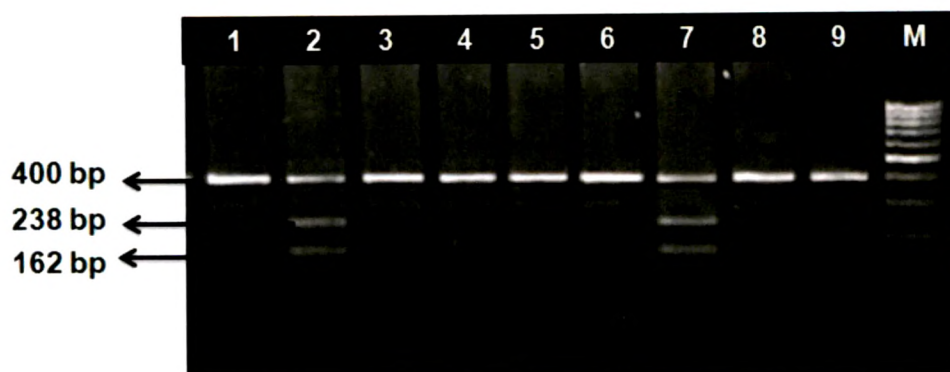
PCR-RFLP analysis of *PTPN22* 1858C/T SNP: 2.0 % agarose gel electrophoresis after overnight digestion of the PCR product with *Xcm*I. Lanes:1, 3, 4, 5, 6, 8 & 9 show subjects with homozygous CC genotypes; lanes: 2 & 7 show subjects with heterozygous CT genotypes. Lane: M shows a 100-bp ladder. No subject with homozygous TT genotypes was observed.
